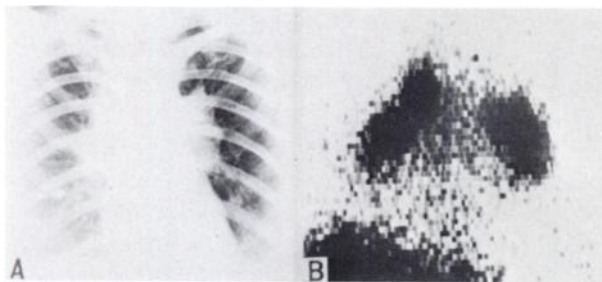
(A) Chest x-ray shows typical shadows of sarcoidosis in hilar region. (B) Scintigram is strongly positive.
